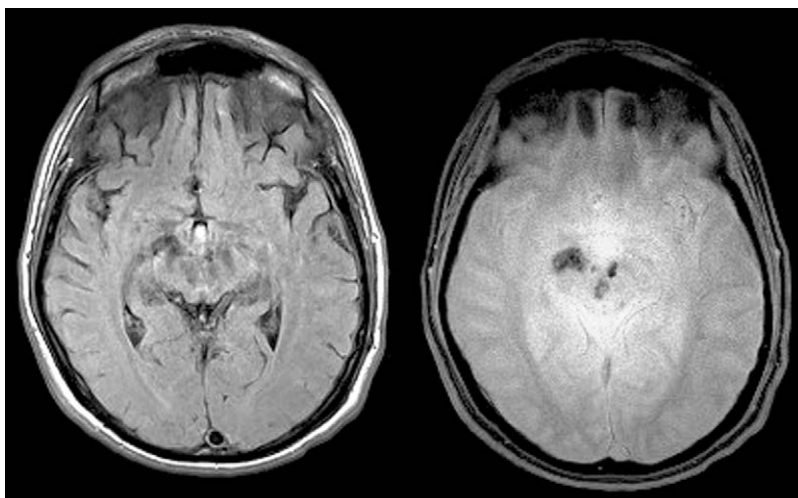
Axial fluid attenuated inversion recovery (FLAIR) (left) and T2* (right) in a TBI minimally conscious patient. T2* sequence shows hypointense in the midbrain suggestive of bleeding not clearly seen on FLAIR sequence.
